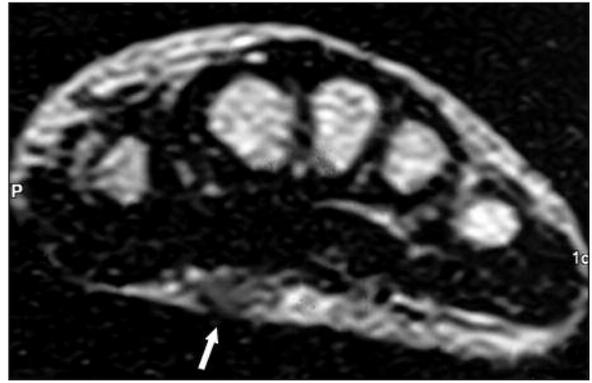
T2-weighted images demonstrated that the mass (arrow) had increased signal intensity.
